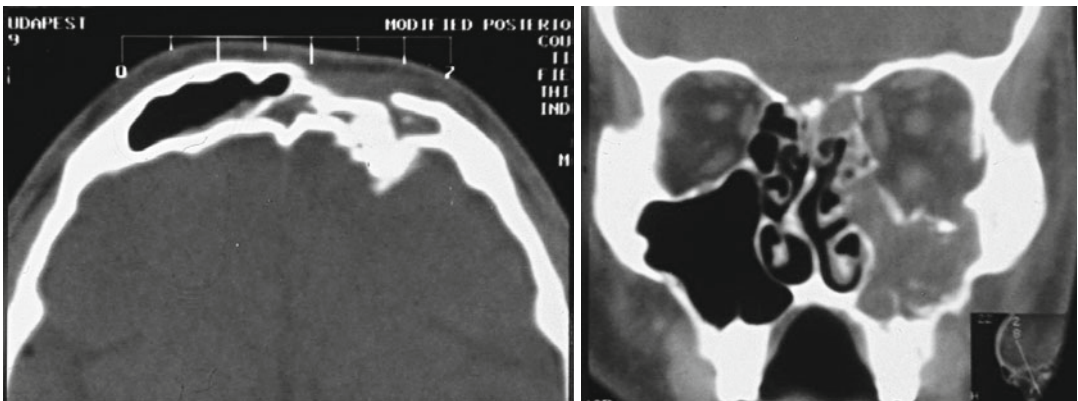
Axial CT image: fragmented fracture of both walls of the left frontal sinus Coronal CT image: dislocated fracture of the inferior orbital wall and the zygomatic bone
